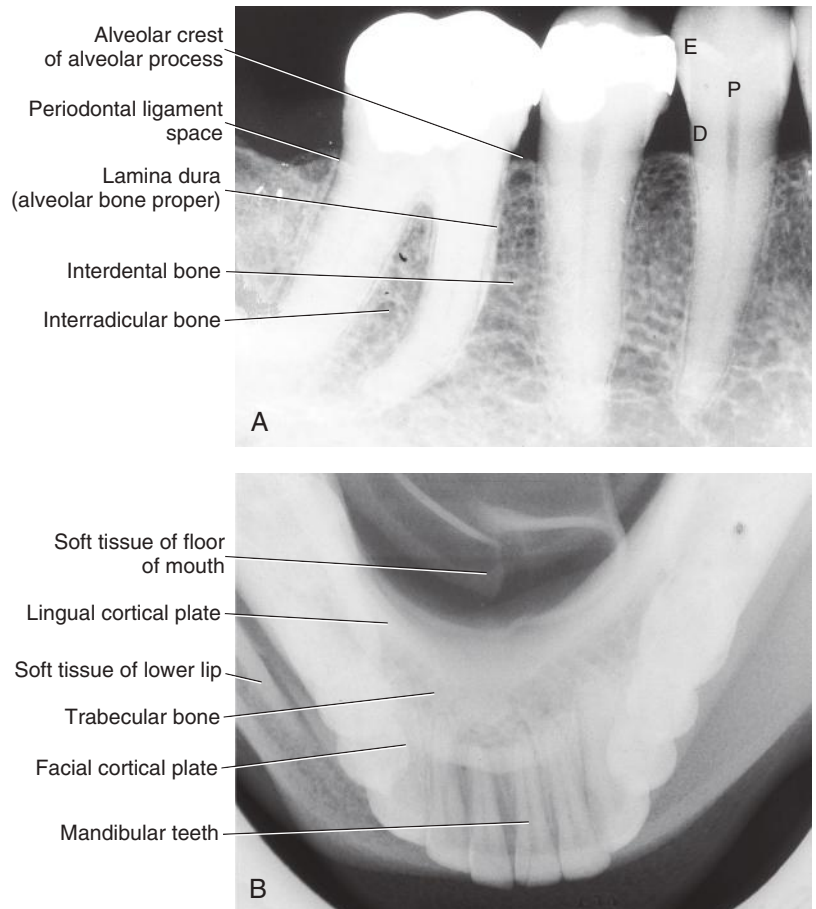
Radiographic landmarks of the alveolar process of the mandible. A, Periapical radiograph. B, Occlusal radiograph. Tooth components are also identified: enamel (*E*), dentin (*D*), and pulp (*P*). (Courtesy of Margaret J. Fehrenbach, RDH, MS.)
